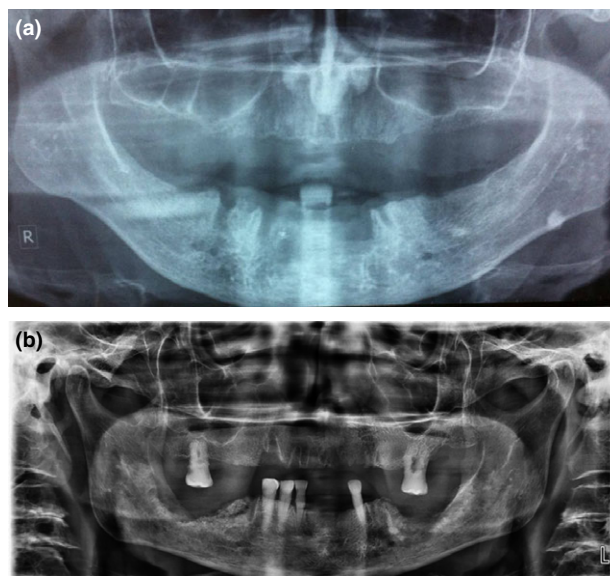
Orthopantomograms of patients who have received radiotherapy (external beam radiotherapy with standard field sizes, conventional fractionation and mean dose 64 Gy) for oropharyngeal cancers. The patients underwent extractions of teeth of the lower jaw after completion of radiotherapy. The orthopantomogram revealed radiolucencies indicating post extraction sockets, which remained visible for longer than 12 months (a), as well as increased radiodensity with mixed radio-opaque/radiolucent lesions, where the radiolucent areas represent bone destruction (b).
